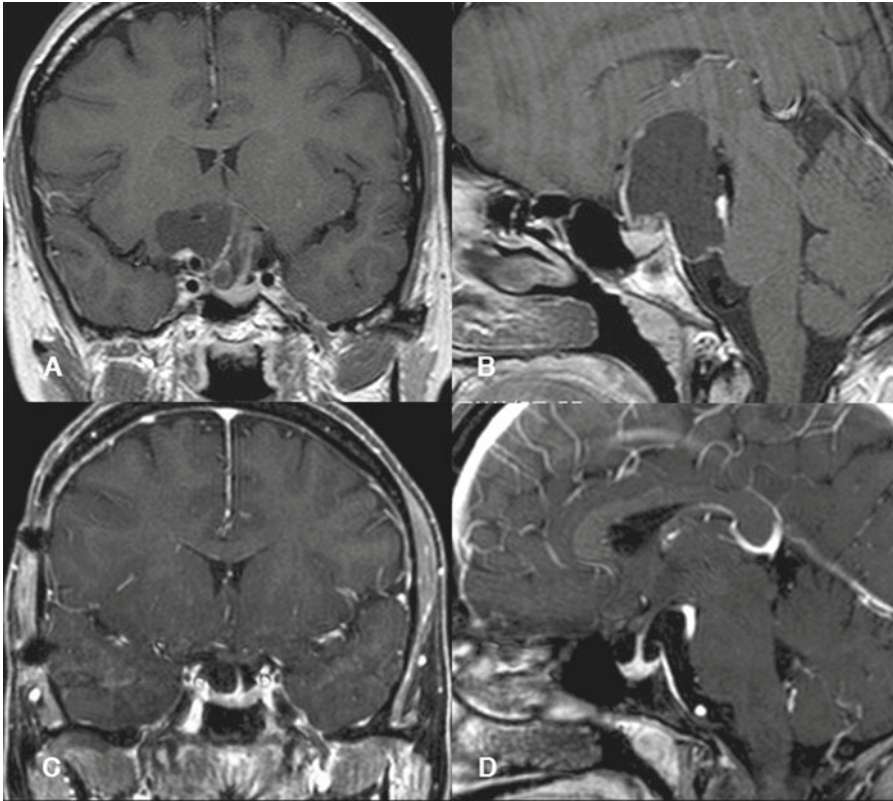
Preoperative and Postoperative MR images. (a, b): Preoperative MRI study; coronal and sagittal gadolinium enhanced T1-weighted images showing the extension of the craniopharyngioma. (c, d): Three
